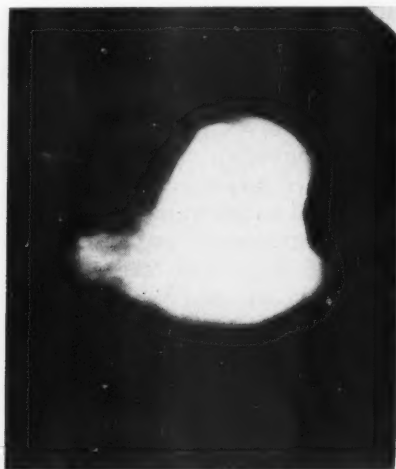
Roentgenogram of the stomach following the ingestion of barium and milk showing the complete retention of the meal. Later exposures showed the stomach emptying in a delayed manner. There appeared to be some partial obstruction at the pylorus.
